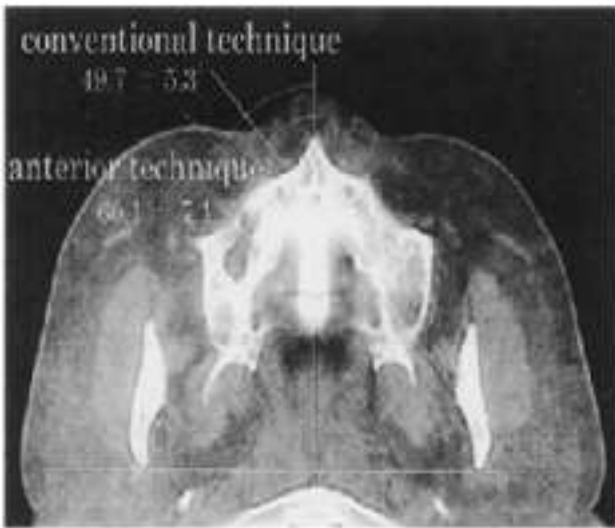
CT images of pterygomandibular space approach
